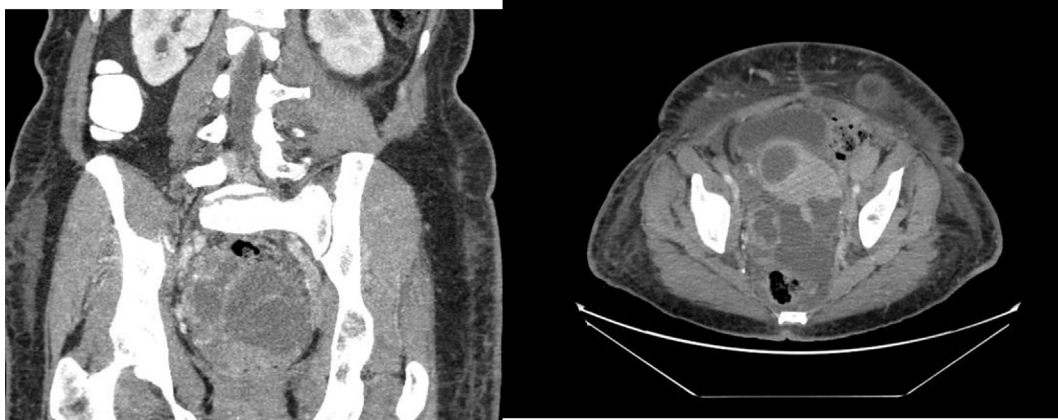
Contrast enhanced computed tomography (CT) of the abdomen and pelvis performed at time of diagnosis of cutaneous metastasis which demonstrates large pelvic mass and bulky retroperitoneal lymphadenopathy with multiple enlarged lymph nodes up to 3.7 cm in size.
